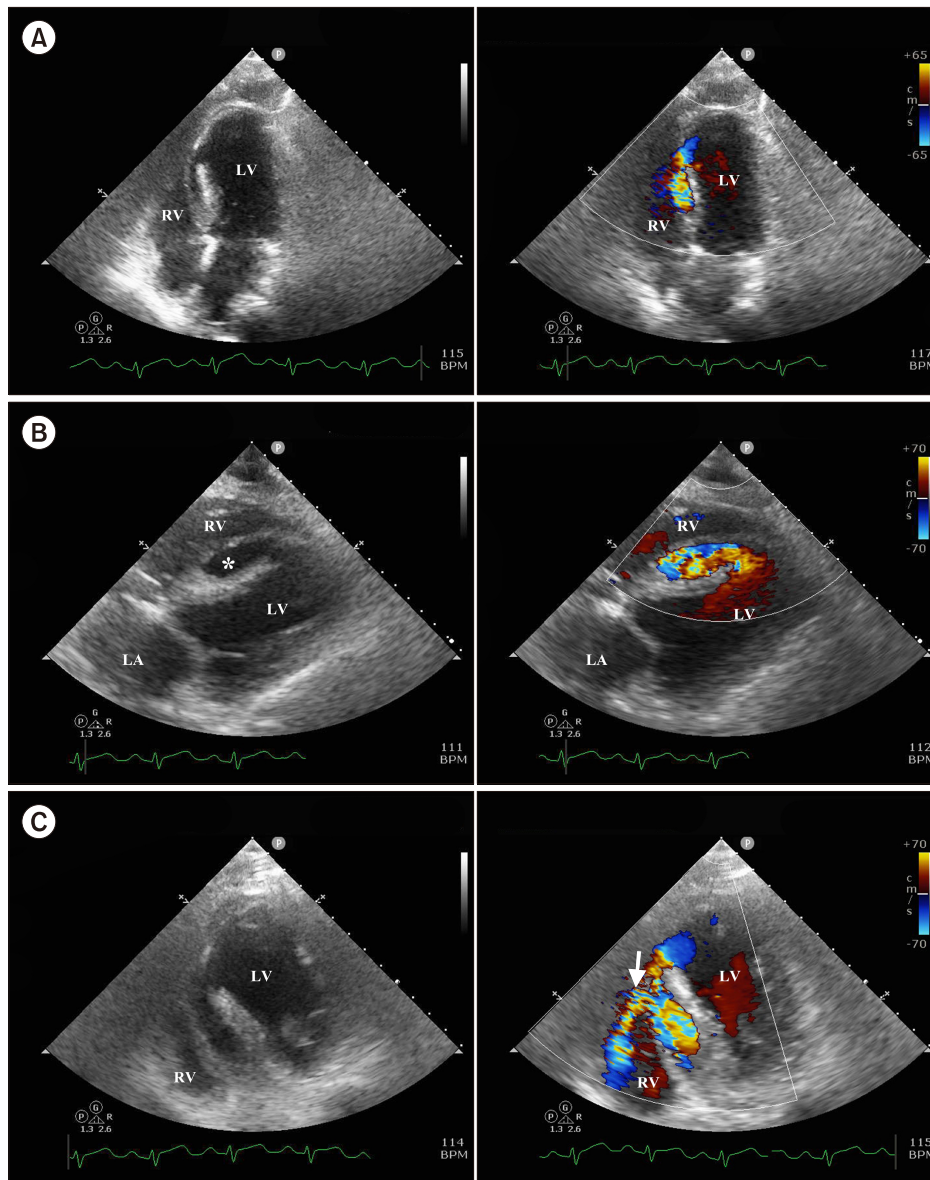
Transthoracic echocardiogram with color Doppler showing a clear jet flow entering the dissecting interventricular septum (asterisk) (A) in apical four-chamber view (B) and subcostal view (C). A shunt flow from LV to RV through the dissected septum (white arrow) is shown in modified apical four-chamber view. LA: left atrium, LV: left ventricle, RA: right atrium, RV: right ventricle.
